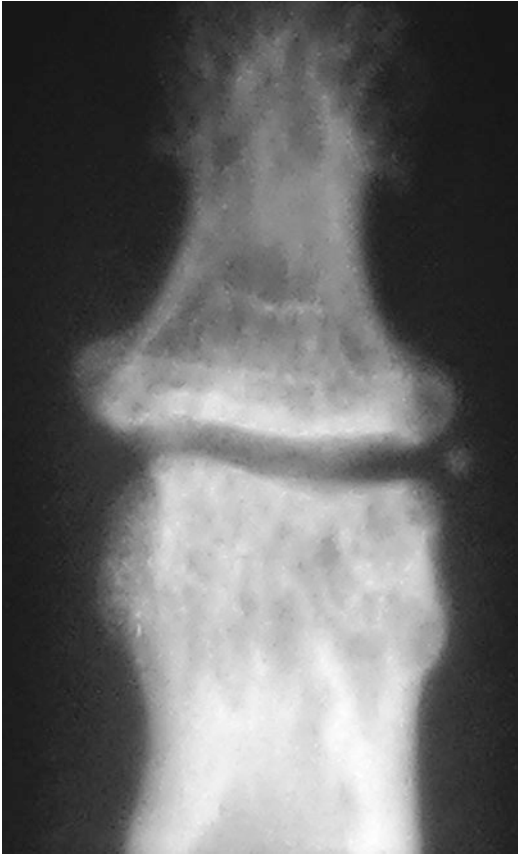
X-ray of the DIP of the same climber: significant widening of the joint surfaces and small periarticular calcification
